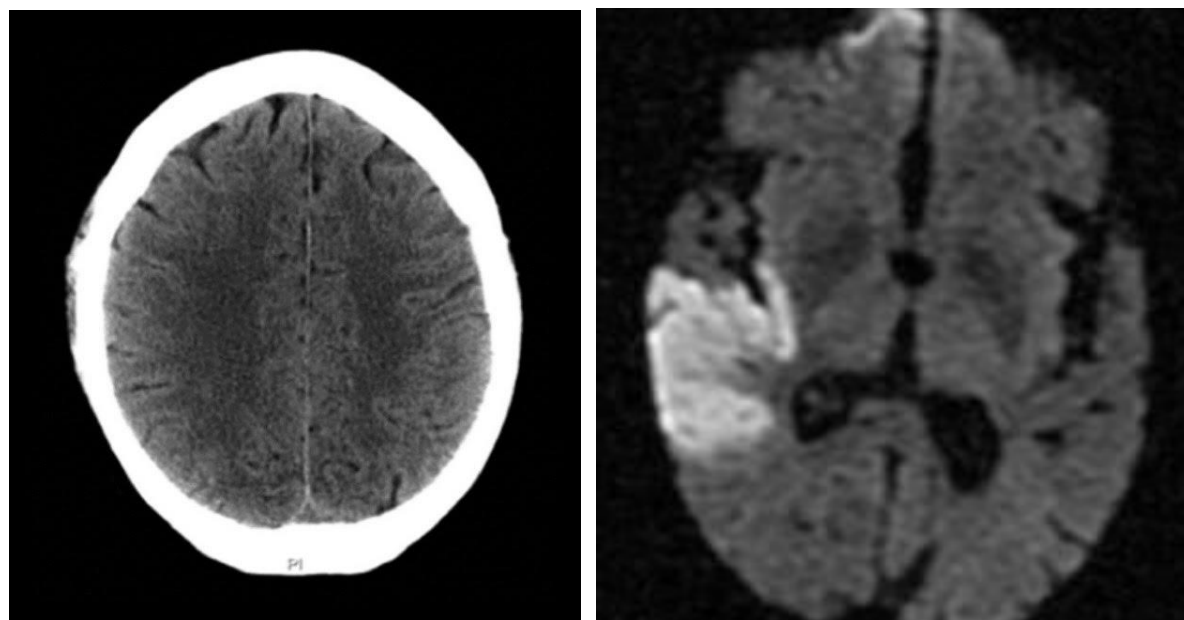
Normal CT scan and Magnetic Resonance (MRI) showing right sided acute ischemic stroke.
